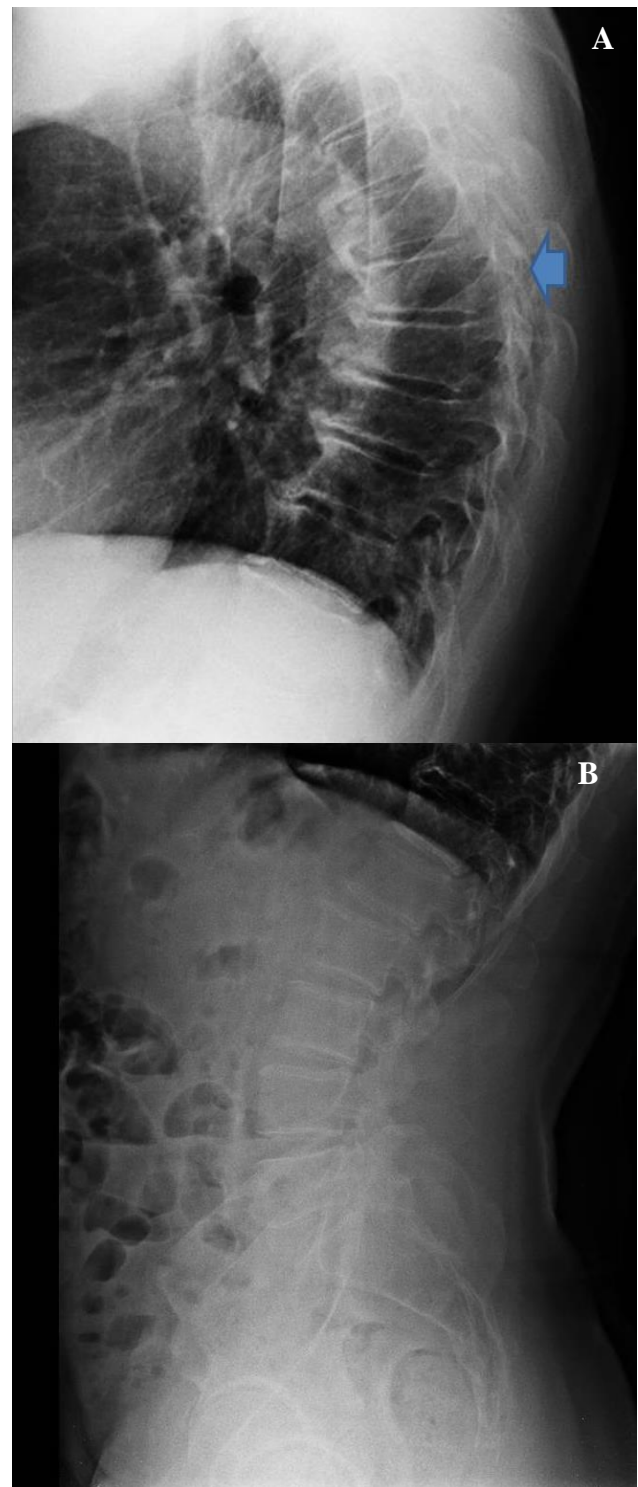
Profile X-Ray of the thoracic (A) and lumbar (B) spine in an acromegalic male. Vertebral fracture is pointed by the arrow
